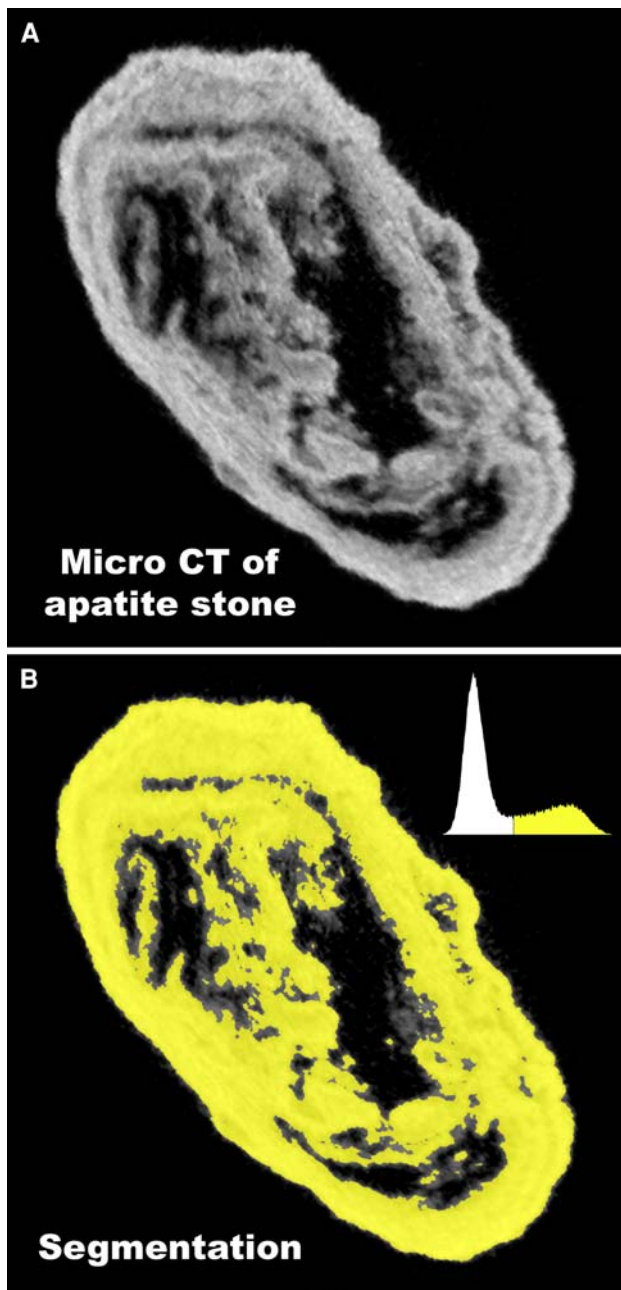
Method for determining volume of X-ray lucent regions (voids) using micro CT. a Micro CT slice of an apatite stone, showing dark regions (voids) within the stone. Total micro CT reconstruction of this stone involved a stack of 243 such slices, each representing 25.5 μm of thickness through the stone. b Stone mineral was segmented using image histogram, shown in *upper right* of panel. Segmented regions were summed in all slices to give total stone mineral volume. This sum was repeated, but including void regions to give total stone volume, and void volume calculated from the difference
